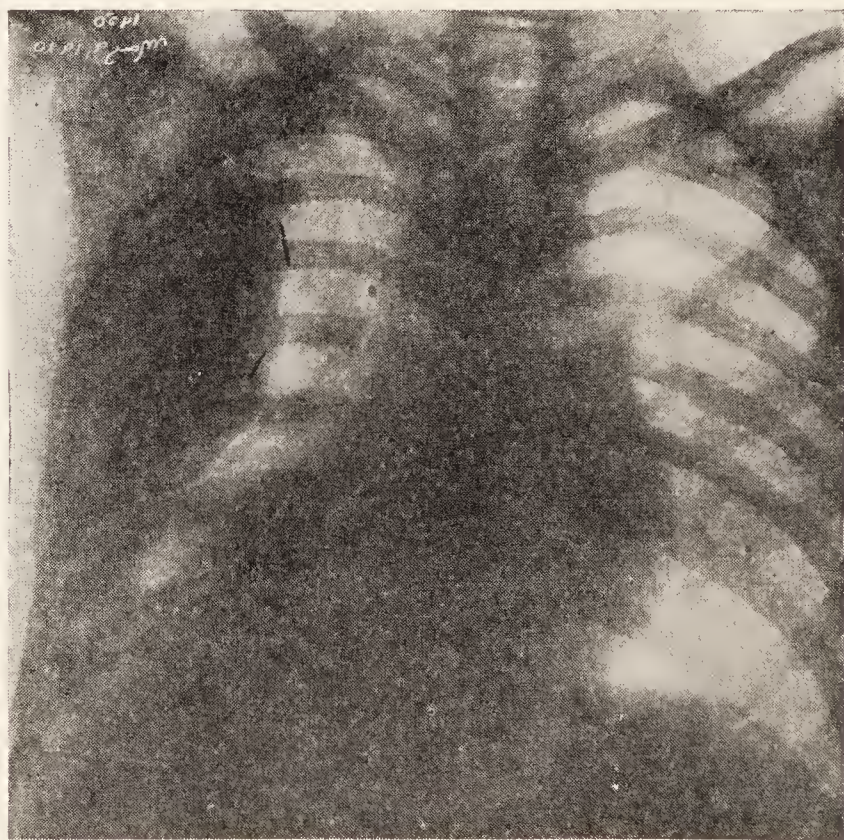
Empyema, left, and pneumonia, right. (Roentgenological Department, Massachusetts General Hospital.)
